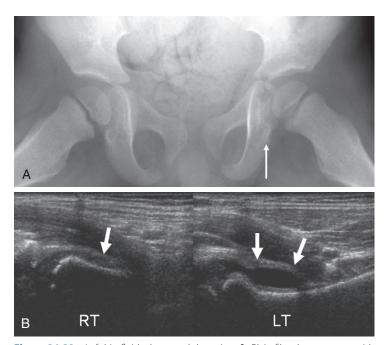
Left hip fluid; ultrasound detection. A, Plain film demonstrates widening of the left hip joint *(arrow)*. B, Ultrasound study of the left hip (LT) in the sagittal plane demonstrates fluid in the bursal extension *(arrows)* over the femoral neck. Also note that the overlying capsule is slightly thickened. Normal side (RT) is shown for comparison. Note that there is no fluid and that the potential bursal joint space over the femoral neck is collapsed *(arrow)*.
